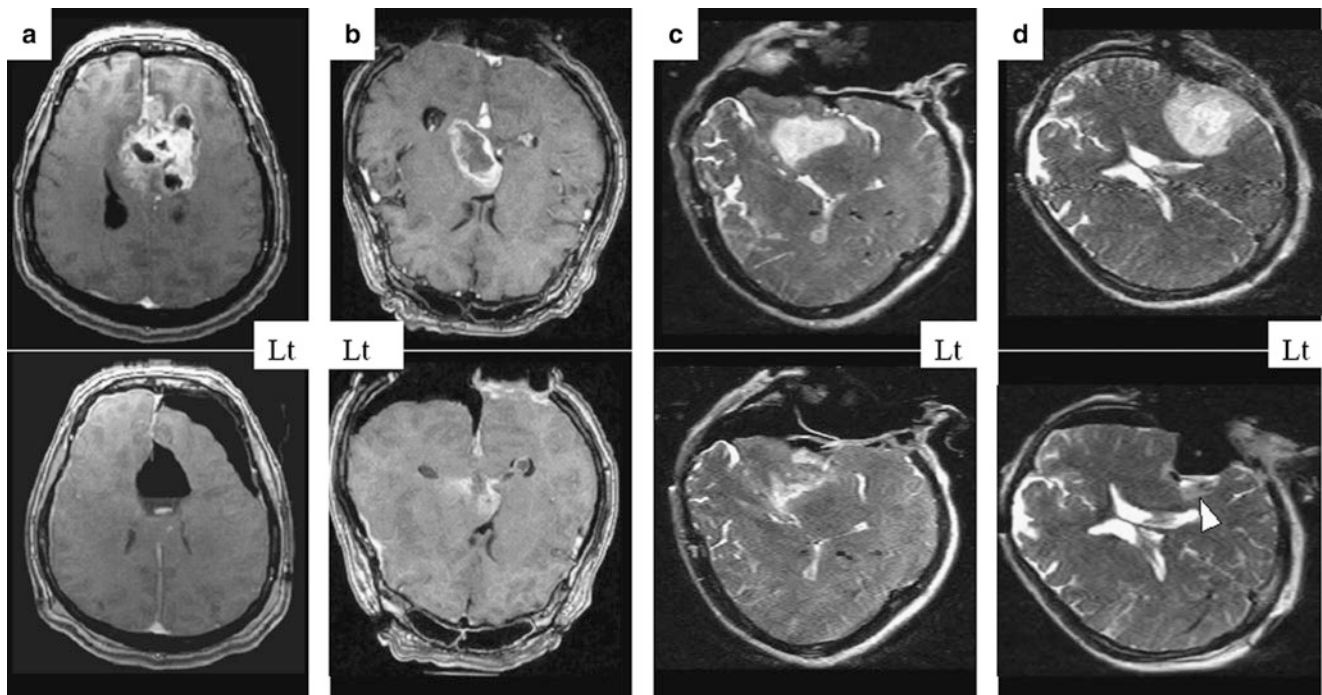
Results of information-guided surgery for glioma using 0.3 T intraoperative MRI. Images before (*upper row*) and after (*lower row*) tumor removal are presented: (a) 100% resection of glioblastoma multiforme of the corpus callosum and both frontal lobes; (b) 85% resection of glioblastoma multiforme of the left thalamus; (c) 98% resection of the low-grade astrocytoma of the left basal ganglia and insula; (d) 98% resection of the anaplastic astrocytoma of the left parietal lobe with residual tumor left in the functionally important brain area (*arrowhead*)
